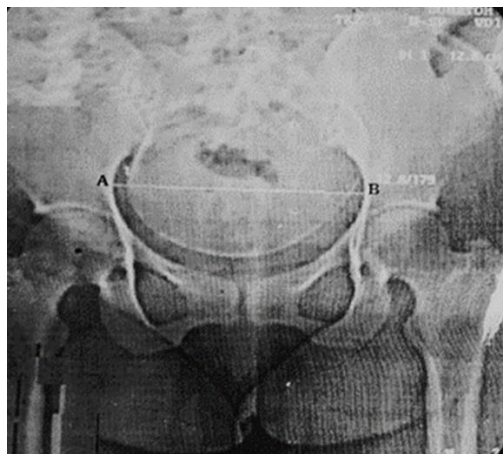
b. CT Pelvimetry showing transverse inlet pelvic diameter measurement
